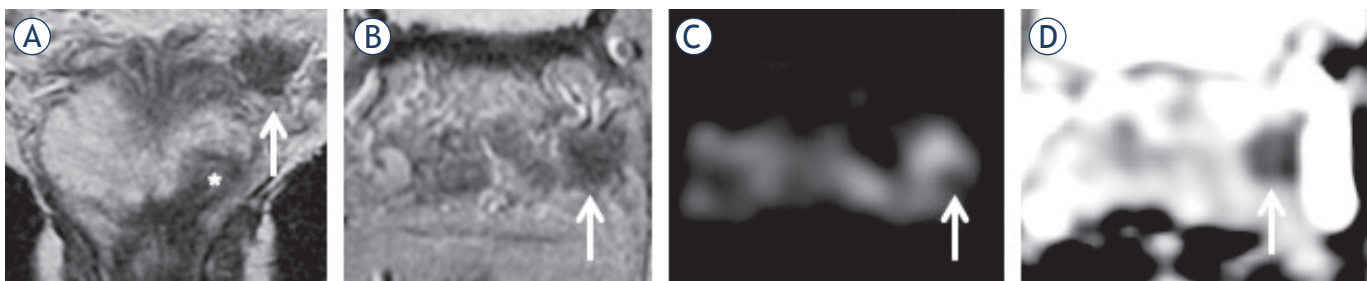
67-yr-old man with raising PSA = 12.7 ng/ml. (A) (coronal) and (B) (axial) T2 weighted (T2W) imaging shows index lesion in the left apex (*) and a low signal focus in the left seminal vesicle (arrow) with corresponding restricted diffusion on diffusion weighted imaging (DWI) ((C); arrow) and apparent diffusion coefficient (ADC) map ((D); arrow).
